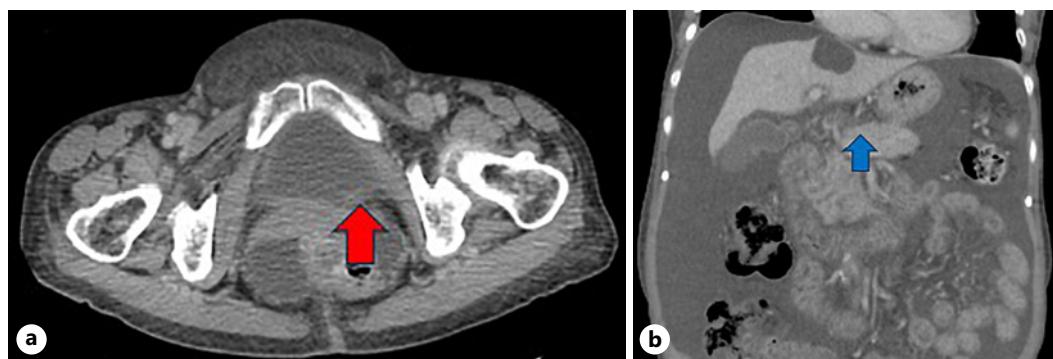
CT images at the judgment of progress of disease after primary treatment. a The presence of pleural ascites and a pelvic dissemination site was noted (red arrow). b The lesser curvature lymph node had reduced in size and was no longer visible (blue arrow). Ascites was observed throughout the abdominal cavity.
